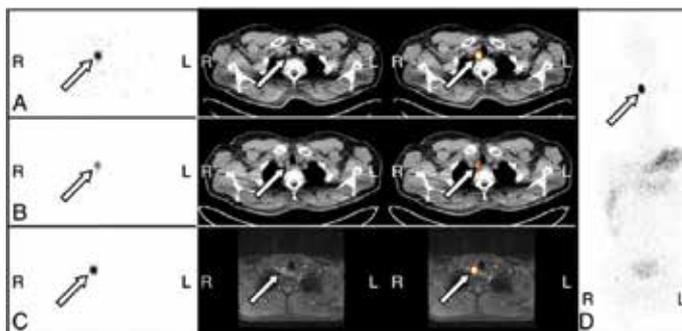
¹²⁴I PET/CT and ¹²⁴I PET/MRI in restaging. A: axial ¹²⁴I PET/CT (after 24 h). B: axial ¹²⁴I PET/CT (after 96 h). C: axial ¹²⁴I PET/MRI (after 24 h). D: ¹²⁴I PET MIP (after 24 h). 44-year-old male patient with a papillary thyroid carcinoma (pT3 pN1b), 1 year after thyroidectomy and RIT with 6.0 GBq ¹³¹I. Thyroglobulin increased without correlate in sonography of the neck. Therefore, a ¹²⁴I PET dosimetry was performed for restaging. The arrows mark one lymph node metastases right cervical paratracheal. On image D stomach, gastrointestinal tract and urinary bladder are visible. The blood dosimetry revealed a MTA of 37 GBq ¹³¹I, until the blood dose of 2 Gy is reached. The lesion dosimetry estimated a LDpA of 14 Gy/GBq ¹³¹I.
